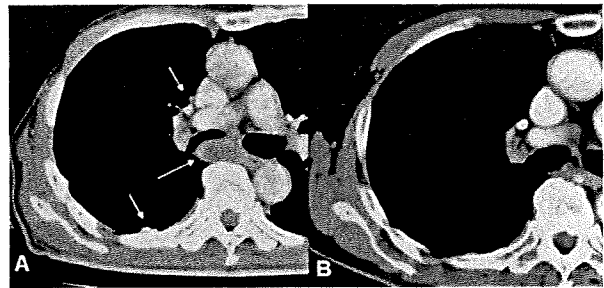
Local relapse before treatment (A) and tumor disappearance after treatment (B) on chest computed tomography. Chest computed tomography scan (A) before the combined therapy showing local relapse of malignant pleural mesothelioma in the right pleural cavity, especially with tumor mass formation in the mediastino-hilar region causing airway narrowing. White arrows show relapsed lesions in the right pleural cavity. After the combined therapy, chest computed tomography scan (B) shows complete tumor disappearance in the right pleural cavity.
